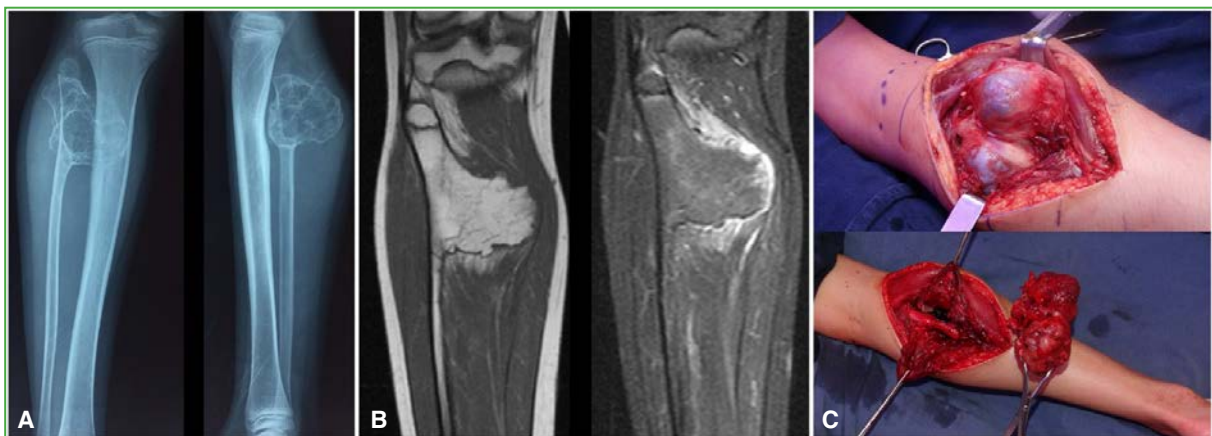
Case 6. A. Anteroposterior and lateral radiographs of the left leg showing a large proximal fibular osteochondroma (135.12 cm³). B. MRI of the same anatomical region, sagittal T1- and T2-weighted sequences. C. Intraoperative images.
